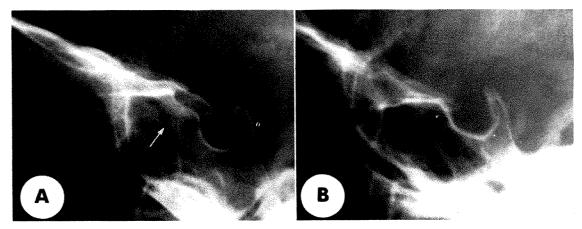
Roentgenograms of children with normal infantile and adult type sphenoids. (A) In the infantile sphenoid, the upper wall of the sinus (arrow) is not in contact with the superior surface of the presellar sphenoid. (B) In the adult type sphenoid, pneumatization of the entire presellar region has resulted in the obliteration of distinct presellar structures.
